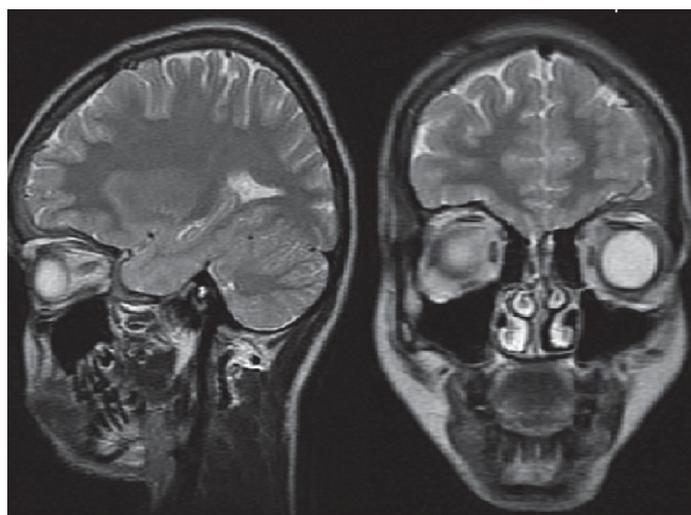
T₂ sagittal and coronal MRI sections corroborating the fluid signal hyper intense sinus and organized hypo intense epidural soft tissue displacing the dural margin without any intra cerebral signal abnormality
